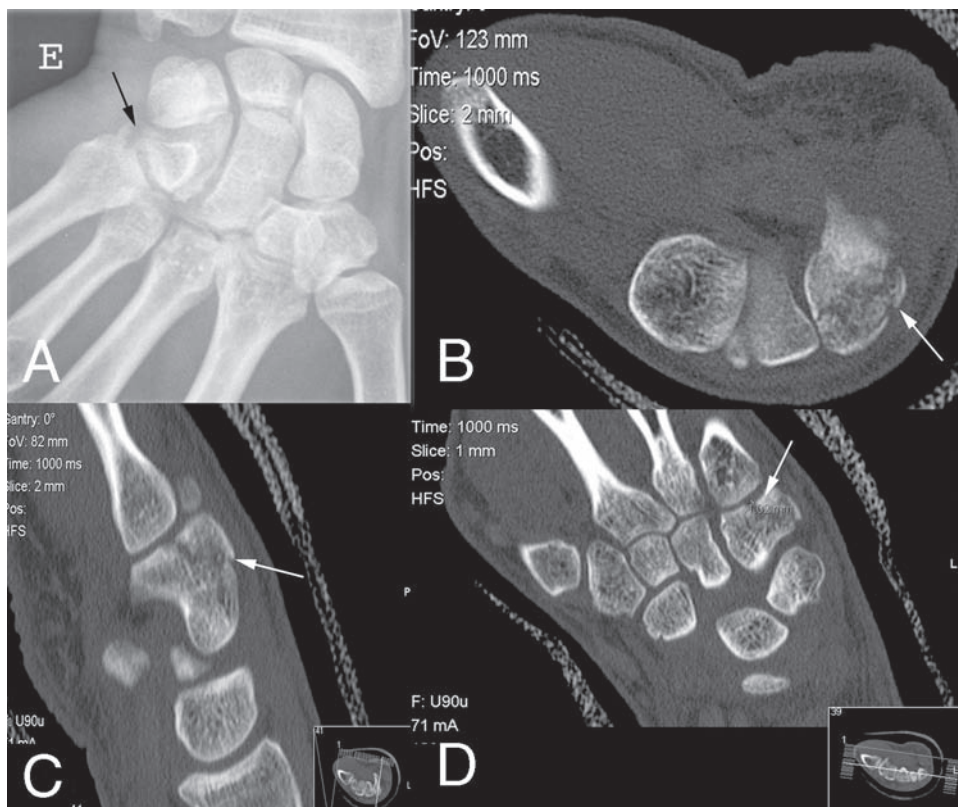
A) Initial x-ray with isolated fracture of the body of the hamate. B-D) Follow-up CT of the fracture at 1 week.
